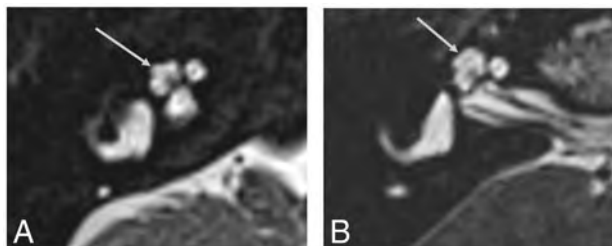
High-resolution 3D heavily T2-weighted MR image of a typical *SIX1*-BOR protuberant "thorny" tip of the cochlea (arrow in A) in comparison with a healthy control in whom the apical turn is uniform and relatively flat and tubular (arrow in B).
